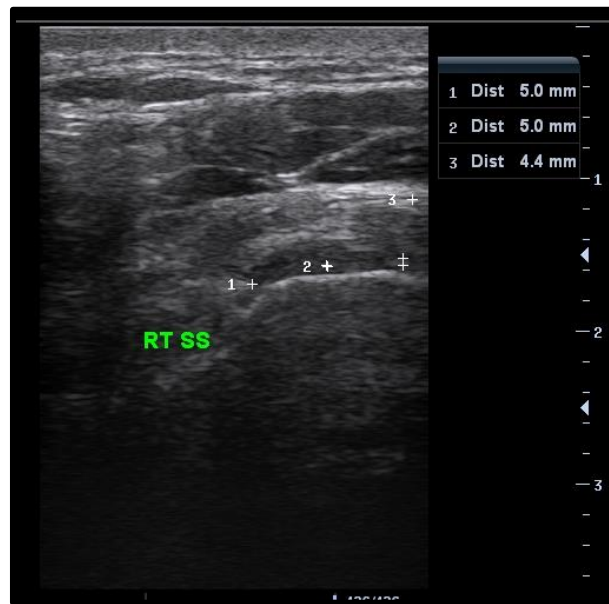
XIII: The ultrasonographic measurement of the supraspinatus tendon thickness.
